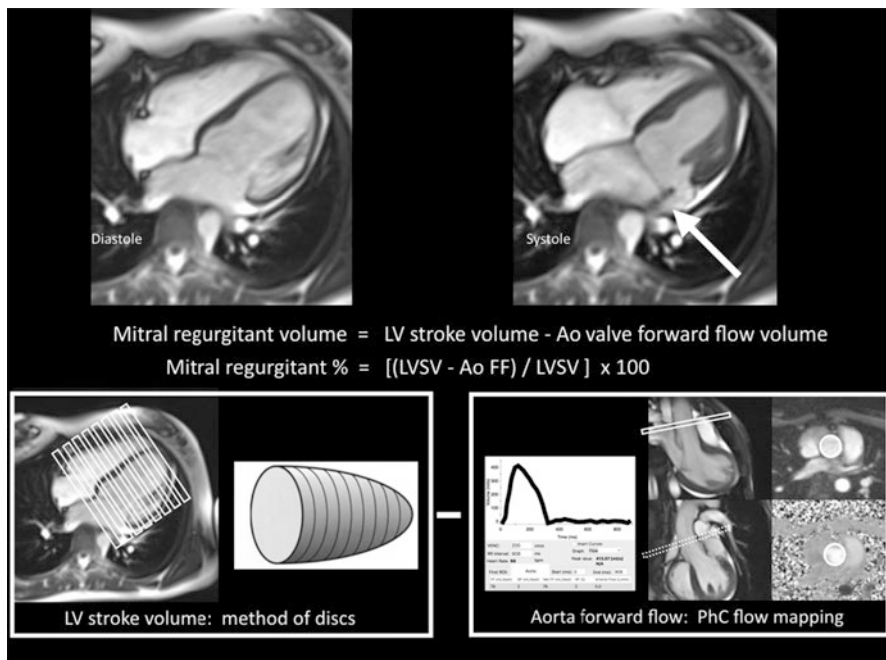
Cardiac magnetic resonance imaging demonstrating assessment of mitral regurgitation severity based on left ventricular total stroke volume and the forward stroke volume through the aortic valve. (Image courtesy of Dr Marina Hughes, Royal Papworth Hospital)
